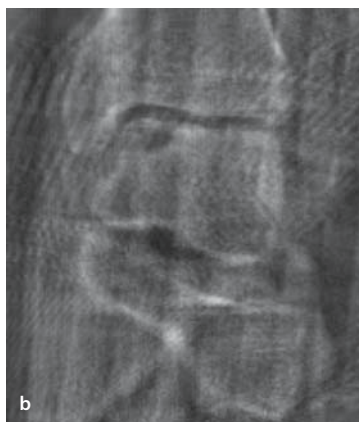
ISO-C-3D-based Computer Assisted Surgery (CAS). ISO-C-3D-based CAS guided retrograde drilling in osteochondrosis dissecans tali. MRI image (a) and ISO-C-3D image from data transferred to navigation system (b) of an osteochondrosis dissecans tali (Berndt & Harty stadium II)
